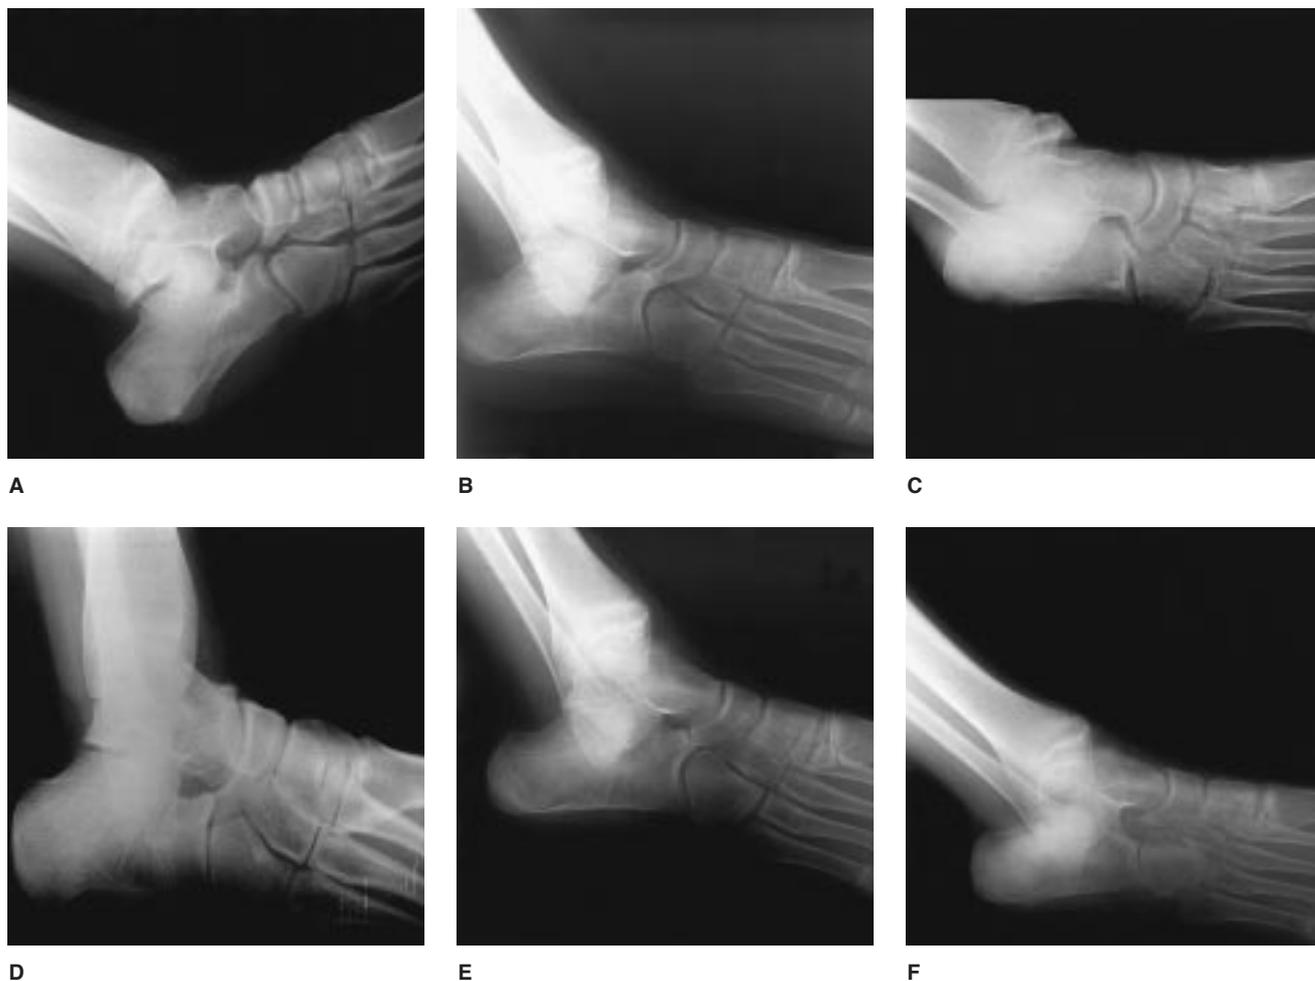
Various appearances of the calcaneonavicular coalition as depicted on 45-degree oblique radiographs of the foot. A, Pointed bone ends with cartilaginous space between. B, Nearly complete coalition. C, Wide bone base and appearance of a pseudarthrosis between the calcaneus and the navicular in a patient with bilateral coalitions. D, When a 45-degree view is taken with the radiograph cassette placed flat on the floor, a "stretched" view of the foot is created, which is sometimes helpful in defining the coalition area. E, A 45-degree oblique radiograph of an 11-year-old with calcaneonavicular coalition. F, Postoperative oblique radiograph of the same patient demonstrates wide bone resection (with extensor digitorum brevis interposition).
